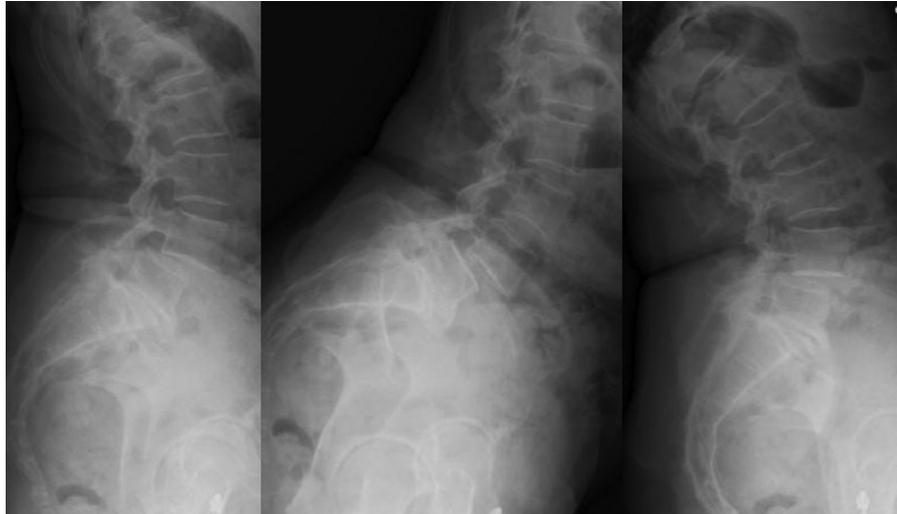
Type C: (Left) neutral, (Middle) flexion, and (Right) extension lateral radiographs demonstrating partial preservation of disc space with more than 5 mm of translation.
